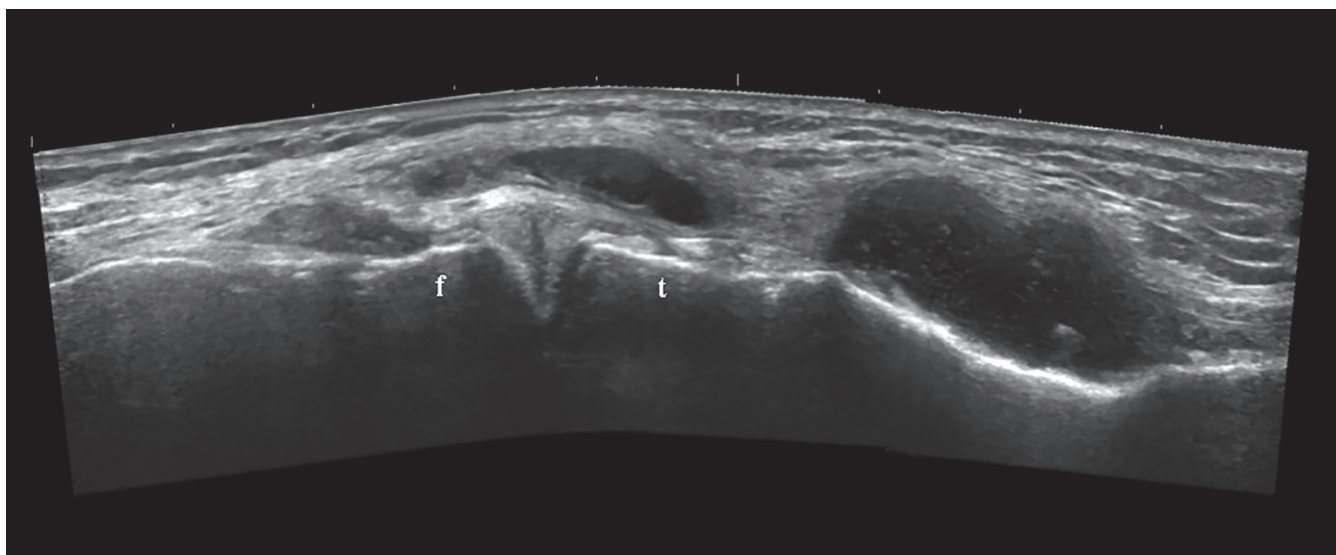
Longitudinal ultrasound image of the medial tibiofemoral space that shows a tear of the anterior horn of the medial meniscus with a meniscal cyst extending to the pes anserinus area in a patient with early knee osteoarthritis. f: femur; t: tibia.
